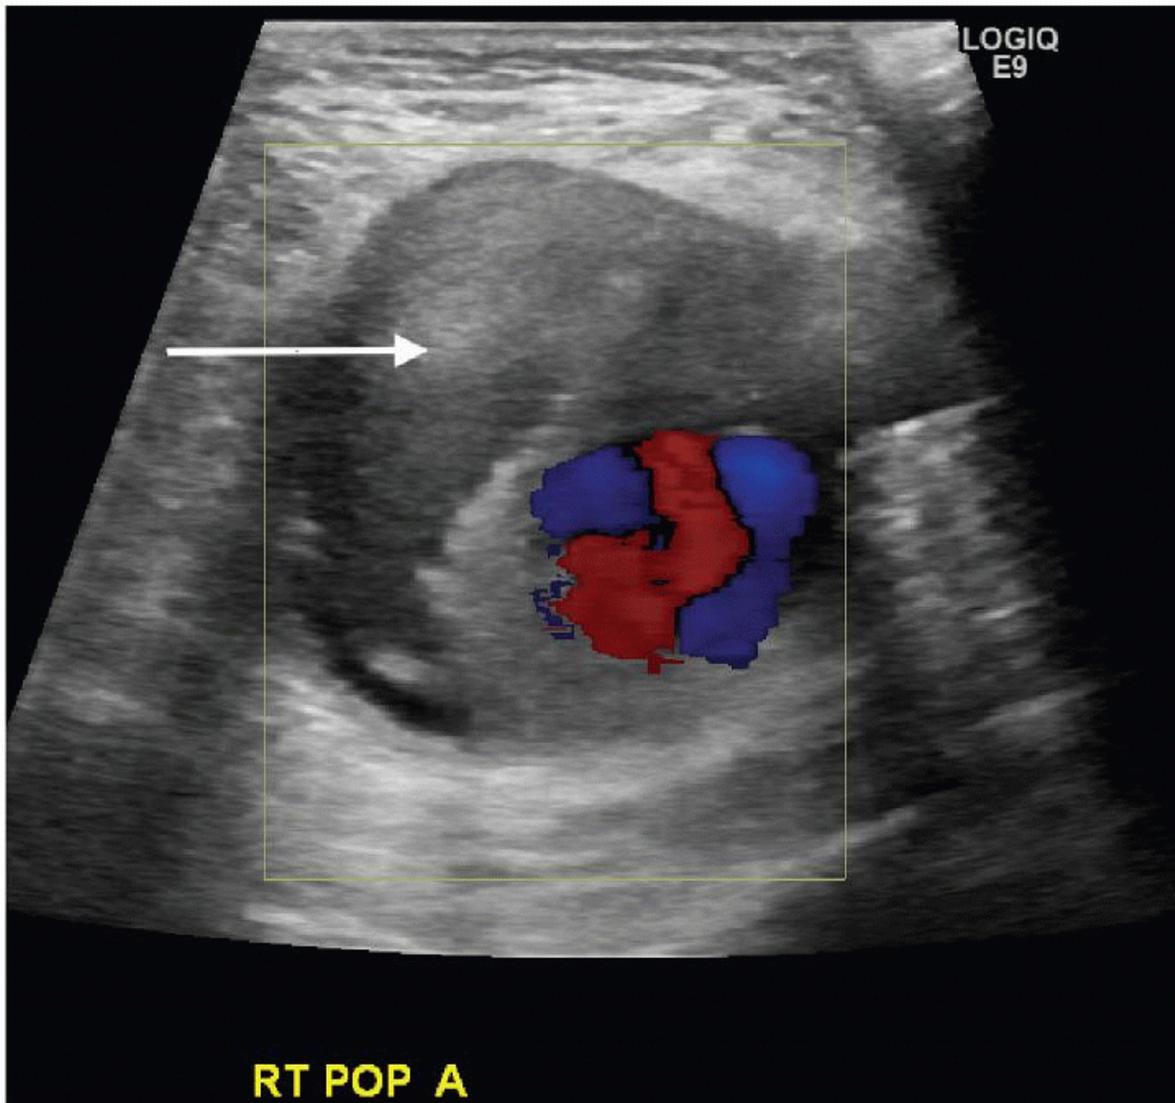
Transverse image demonstrating a large popliteal aneurysm with dissection. Arrow, region of dissection. Color Doppler demonstrates patent lumen.
